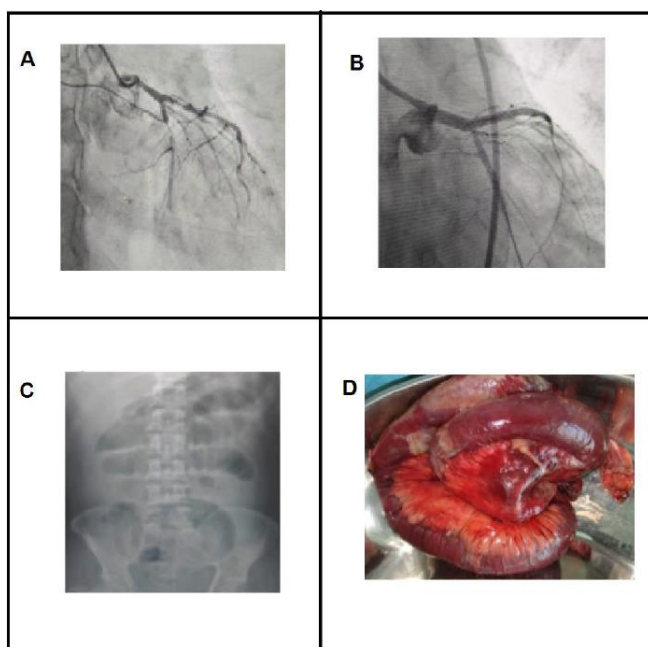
(A) Fluoroscopy images during percutaneous coronary intervention before stent implantation, (B) After stent implantation; (C) Multiple air-fluid levels in X-ray erect abdomen and (D) resected bowel segment with areas of necrosis.
